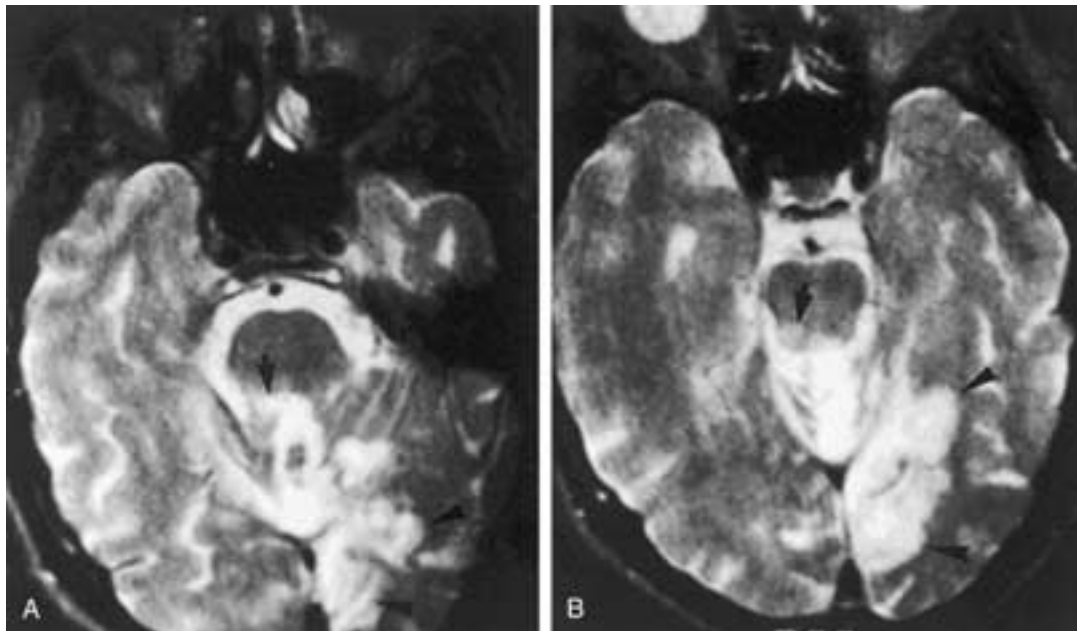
Left occipital lobe, midbrain, and upper brainstem infarction. A, Axial T2-weighted image shows hyperintense signal intensity at the site of the left occipital lobe infarct (arrowheads). Note the hyperintense focus of infarction in the periaqueductal region of the upper pons (arrow). B, Slightly higher axial T2-weighted image shows the further superior extent of a hyperintense infarct involving the left occipital and medial temporal lobes (arrowheads). A high signal intensity focus is present in the dorsal aspect of the right midbrain (arrow).
